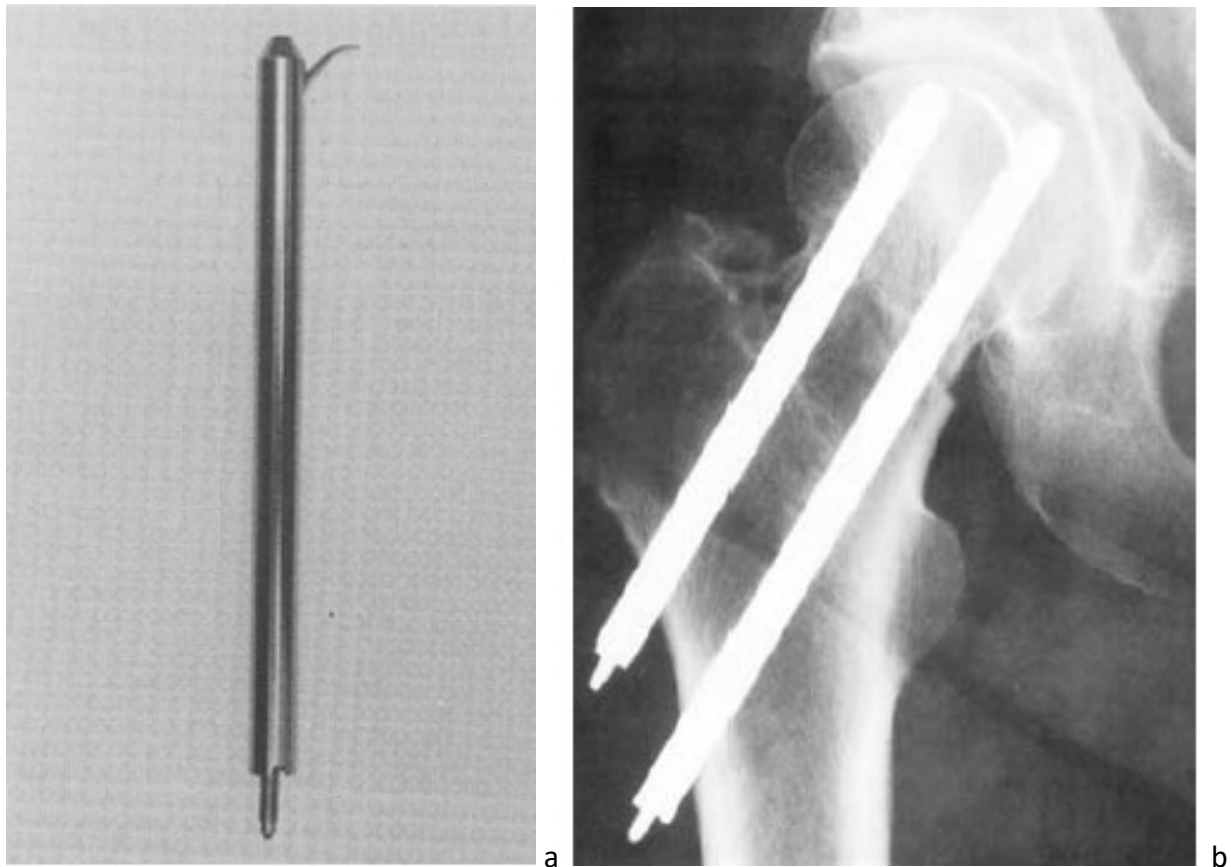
Photograph of Hansson hook pin (a) and radiograph of Hansson hook pins for a femoral neck fracture. Reproduced with permission from Springer (licence number: a. 4450960195677, b. 4450941137684); (a.[14], b.[9]).
